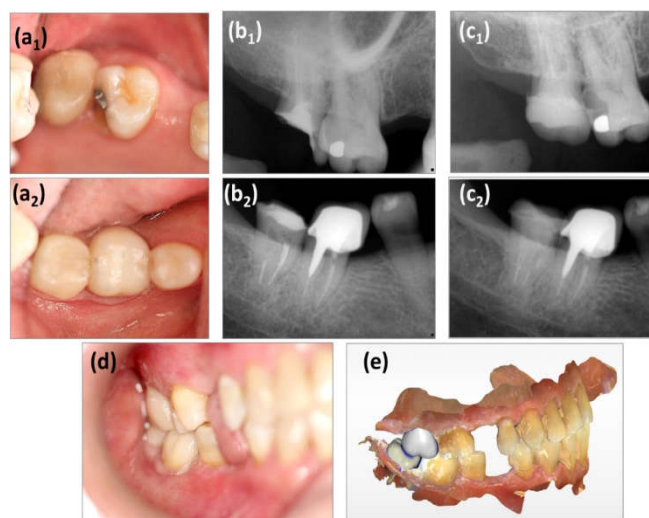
Occlusal view of the second molars of the maxilla (a1) and mandible (a2) after cementation and polishing of the endocrown restorations. Periapical radiographic images before (b1 and b2) and after (C1 and c2) of the endocrown restorations in the upper and lower second molars. In panoramic (d) and digital (e) views, we can see good dental occlusion of the restored antagonist molars
